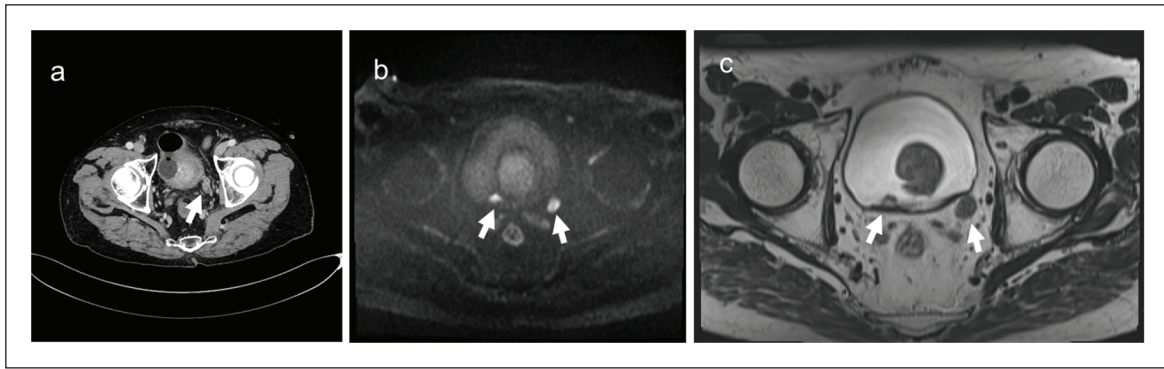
Computed tomography (CT) at the time of admission shows a left lower ureteral tumor (a: arrow). A high signal intensity on diffusion-weighted imaging (b: arrow) and a low signal intensity on T2-weighted imaging (c: arrow) of magnetic resonance imaging show multiple non-muscle-invasive tumors from the posterior to right wall of the bladder and the muscle-invasive tumor in the lower part of the left ureter.
